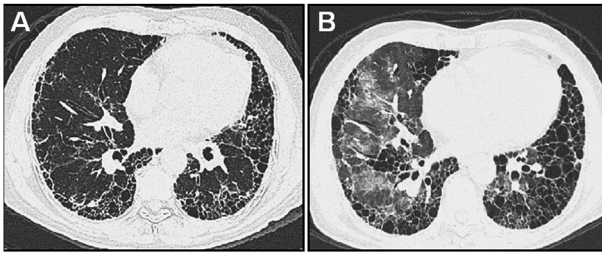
Acute exacerbation. High-resolution computed tomography showing a pattern of typical usual interstitial pneumonia in panel A and the presence new bilateral ground glass attenuation over imposed on the previous UIP lesions in panel B.
